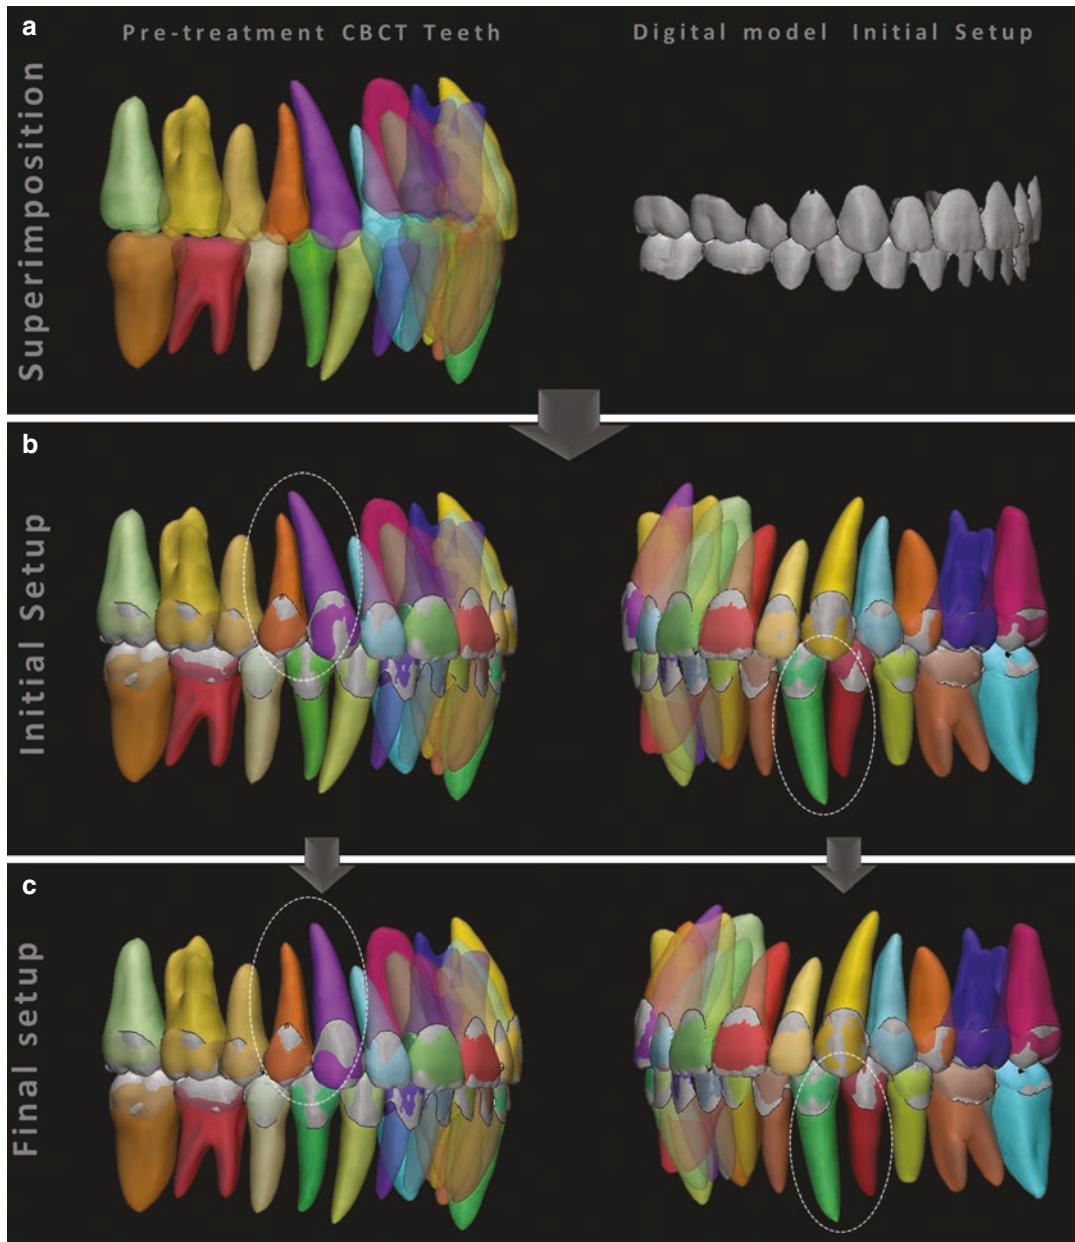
(a) Pretreatment CBCT showing the tooth position and root angulation. On the right side showing a setup done using the scanned model. (b) Showing left and right side of the initial setup. The roots from the CBCT were
